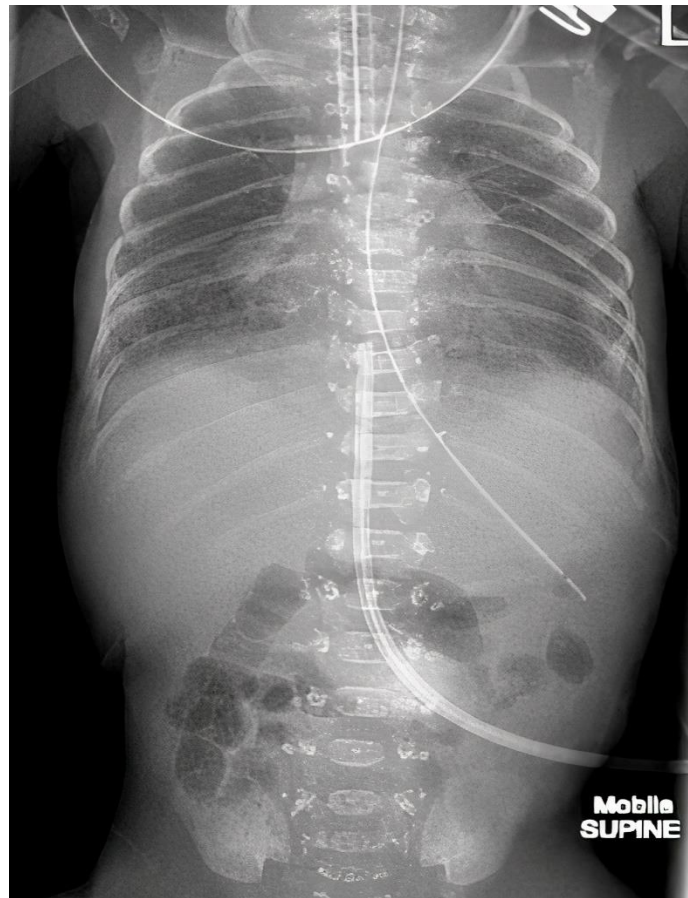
Radiograph showing florid chondrodysplasia punctata.
